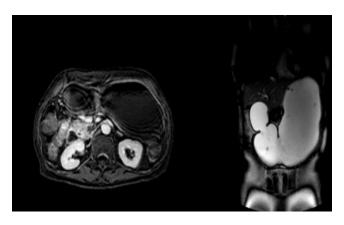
Magnetic resonance imaging shows pyloric widening resulting in decreased amplitude of the pyloric channel, with significant distension of the first and second portions of the duodenum.
